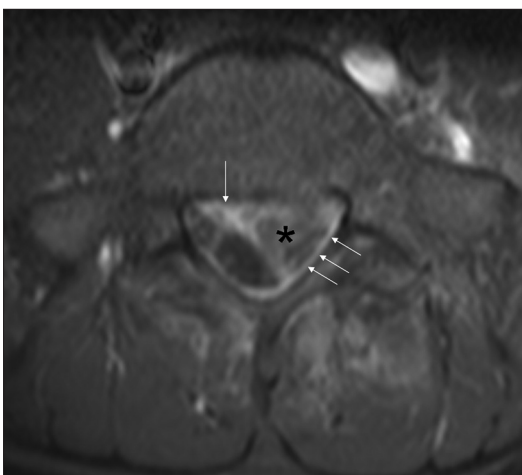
Axial, T1-weighted MR images with Gadolinium injection showing right posterior epidural enhancement and along the left lamina of S1 (white arrows) with spinal epidural abscess (asterisk)
